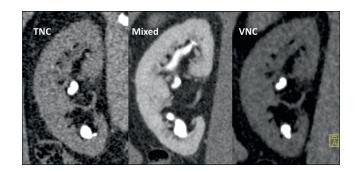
Coronal reconstruction of TNC CT and dual energy, split bolus CT in patient with urinary stone disease. Mixed image shows iodine contrast medium in parenchyma and urinary system. VNC reconstruction shows stones remaining after subtracting iodine contrast.
